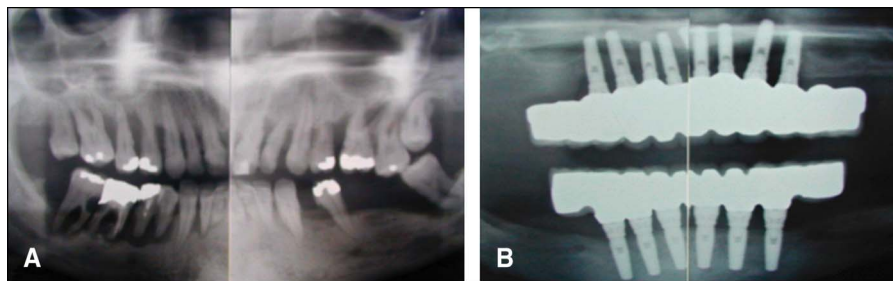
A, Radiographic view of the oral condition of a 44-year-old patient who presented for an implant consult. Note the extensive loss of alveolar bone because of severe periodontal disease. B, The patient restored with fixed prostheses in both jaws, after placement of 8 and 6 implants in the upper and lower jaw, respectively, based on the principles of conventional implant treatment planning, as demonstrated in this 36-month panoramic radiograph.
